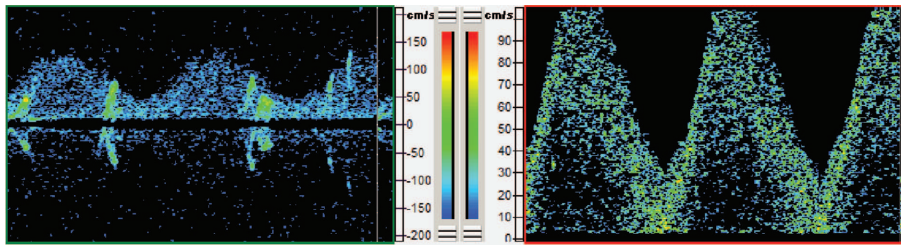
2-MHz (left) and 8-MHz (right) Doppler spectrogram showing pulsatile flow profile enhancements caused by air bubble injection.
